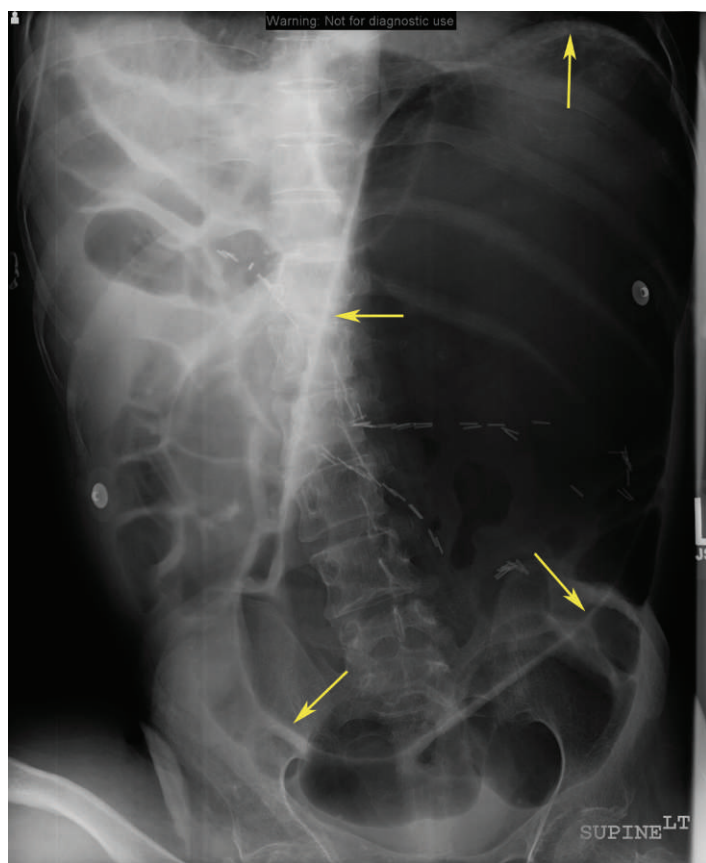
Abdominal radiograph showing massive gastric distension outlined by arrows.
